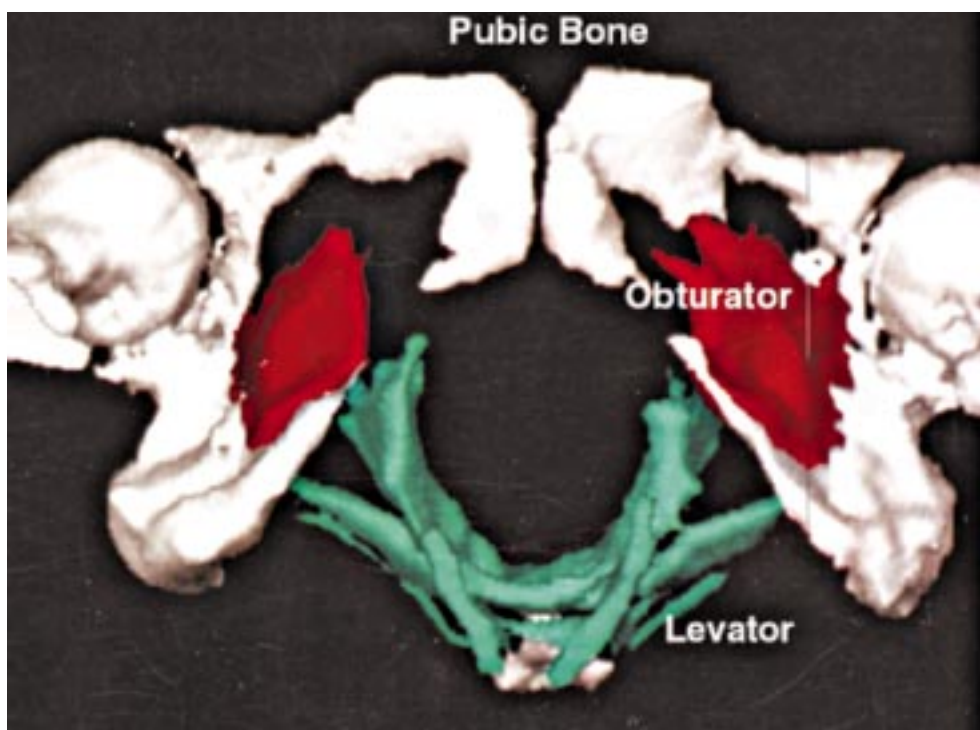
3D MRI of pelvic floor : 3D reconstruction of levator ani anatomy
